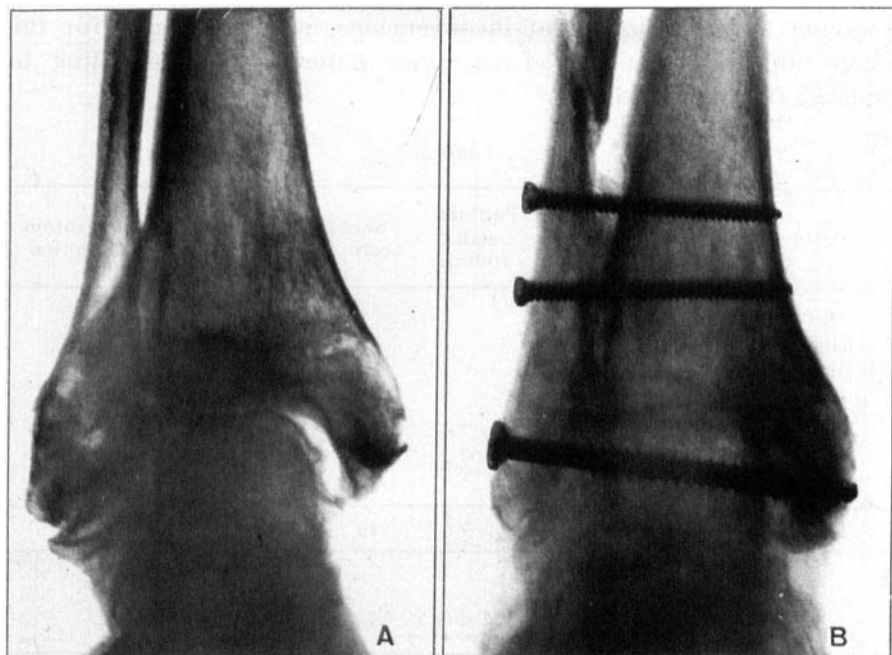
a) Radiograph of an ankle showing osteoarthritis after fracture. b) The same ankle as in a) four months after arthrodesis by the method of Adams.
